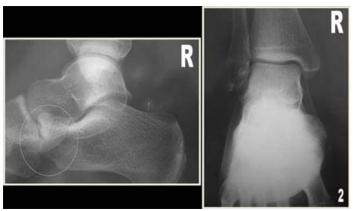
The more recent radiographs of the ankle, from 2008 show the region of abnormality particularly well demonstrated on the lateral view (oval).
